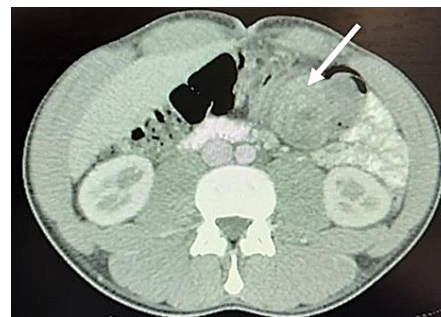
Contrast-enhanced computed tomography of the abdomen, axial view. A 43 × 30 mm solid intraluminal lesion is identified in the distal transverse colon, demonstrating minimal enhancement after contrast administration. A “target sign” pattern is also observed (arrow), suggestive of intussusception secondary to an underlying structural lesion acting as a lead point.
